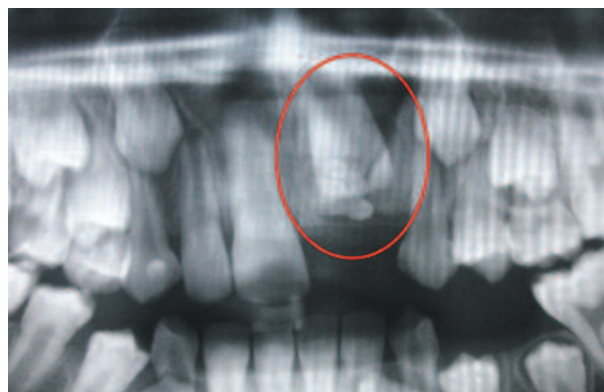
Panoramic radiograph taken one week after the operation; Impaction of the upper left central incisor.
